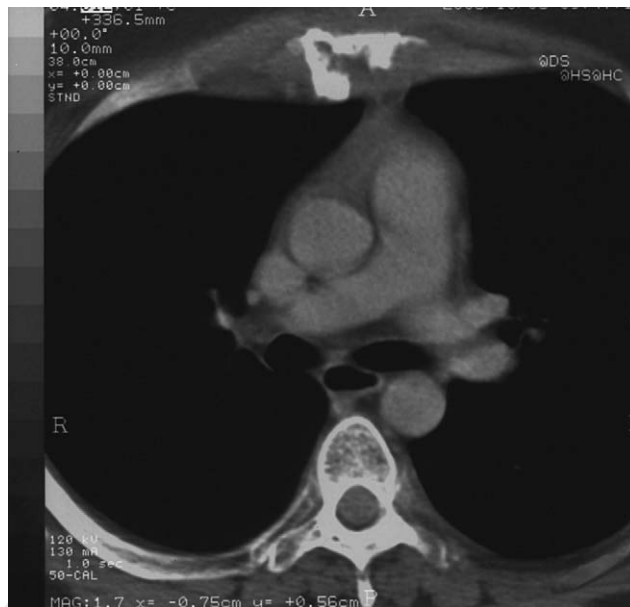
Contrast enhanced CT of thorax revealing osteolysis and destruction of the mid-third of the sternum.
